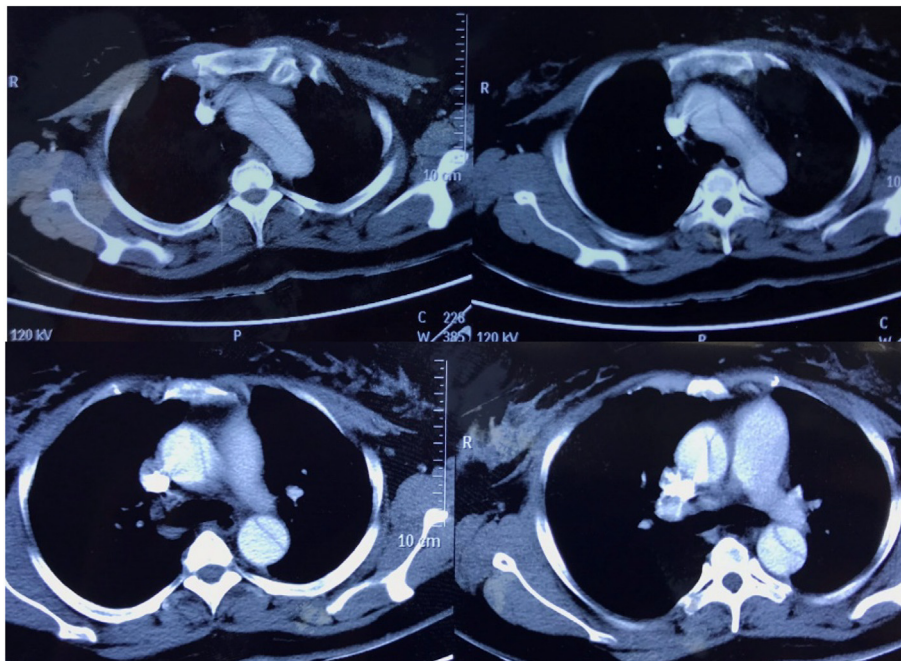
Chest computed tomography scan of acute dissection in the ascending and descending aorta.
